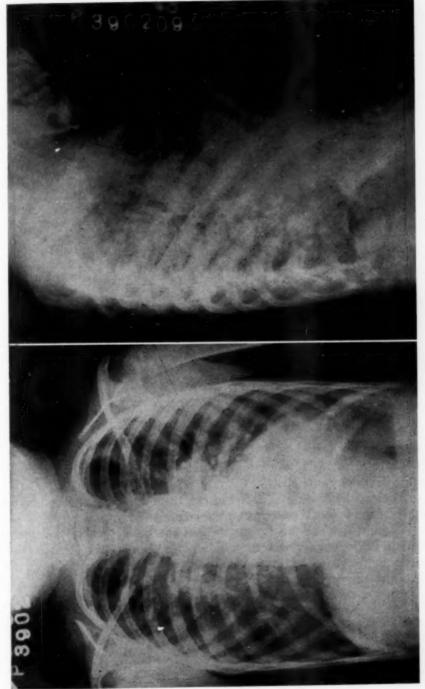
Roentgenogram of chest in case of Eisenmenger's complex.
